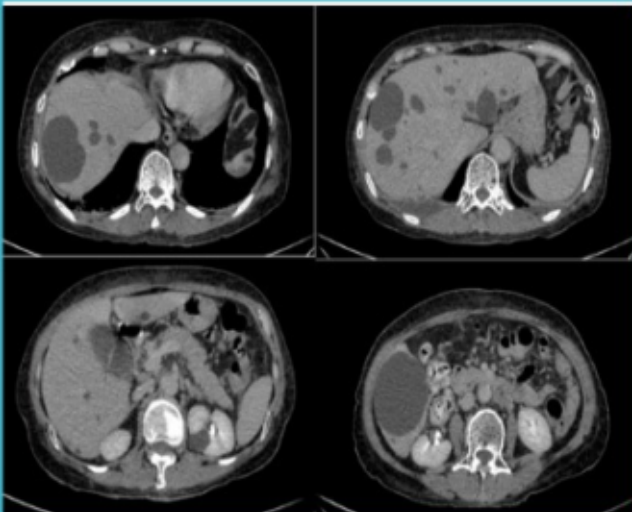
Abdominal CT scan with contrast examination showed multiple simple liver cysts on both liver lobes and simple left kidney cyst.
